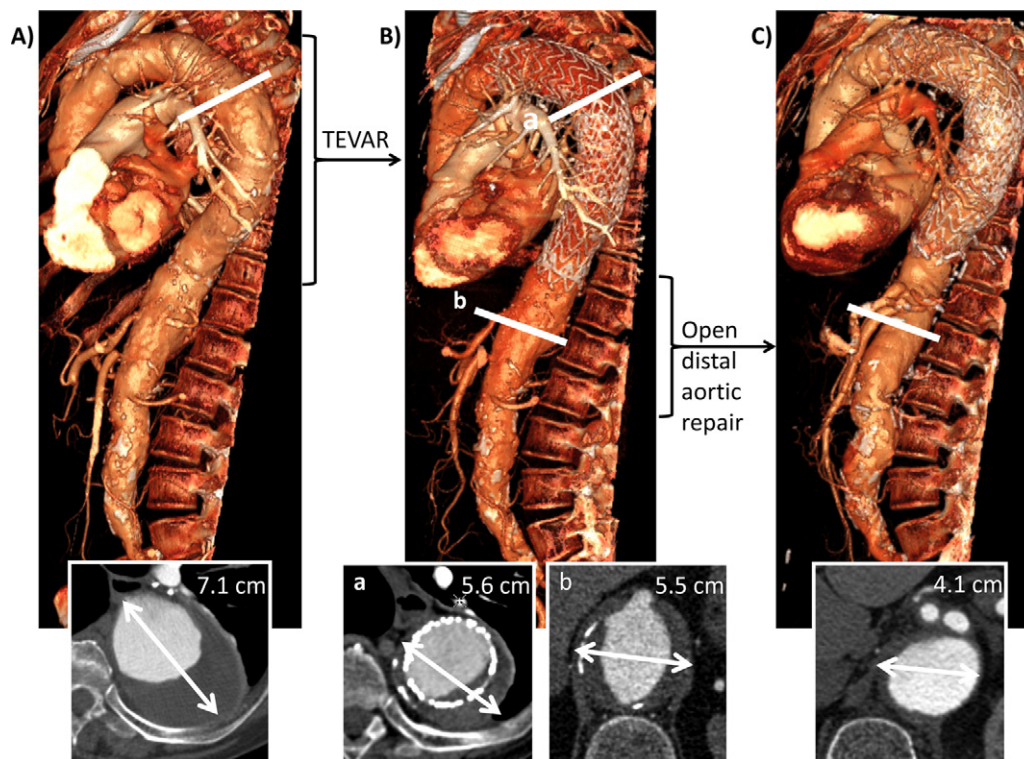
Approach to staged hybrid thoracic endovascular aneurysm repair (TEVAR)-open surgery (OS) repair for extensive thoracoabdominal aortic aneurysms. Three-dimensional reconstructions from computed tomography (CT) angiography are shown with sample cross-sectional CT images shown below, corresponding to the level of the *white line* in the aortic CT reconstructions. A, A patient presented with a 7.1-cm extent II thoracoabdominal aortic aneurysm secondary to a penetrating aortic ulcer that was treated initially with proximal TEVAR. B, Following TEVAR, the proximal aorta remodeled from 7.1 cm to 5.6 cm (cross-sectional image *a*). However, distal thoracic and abdominal aortic expansion occurred (cross-sectional image *b*), which was treated with open distal aortic repair (C).
